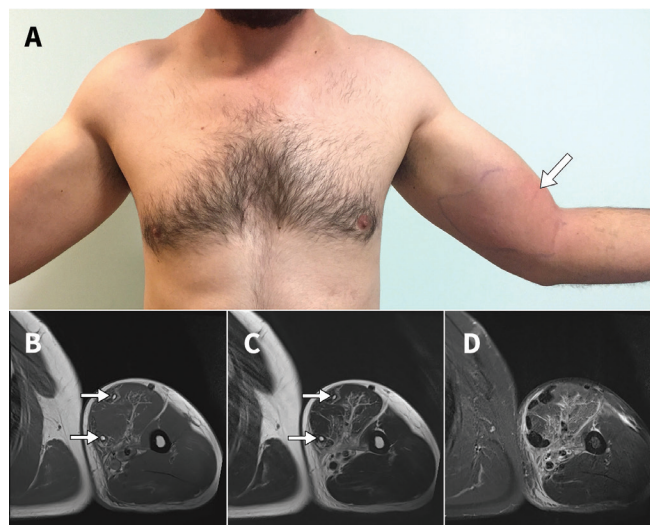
(A) Photograph of a 32-year-old amateur bodybuilder showing an erythematous patch over his left bicep (arrow), (B) axial T_1 -weighted magnetic resonance imaging (MRI) and (C) axial T_2 -weighted MRI showing hyperintensity (arrows), and (D) axial short tau inversion recovery MRI showing nodular areas of marked signal hypointensity.
